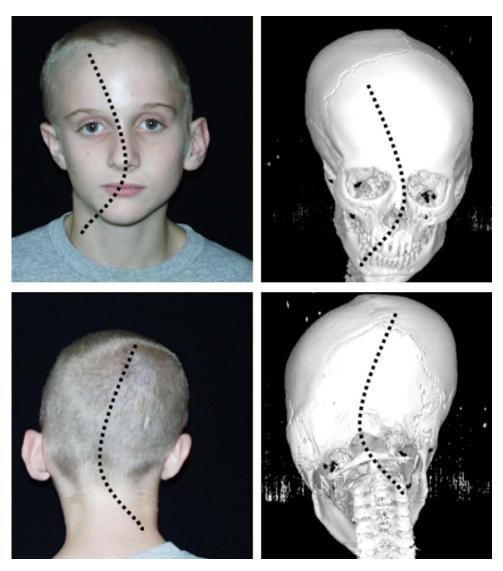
Clinical photographs and the corresponding 3D head CT images demonstrating the appearance of C-shaped facial scoliosis (dotted line) seen in a 12-year-old patient. Contralateral parietal bossing, ipsilateral ear prominence, and ipsilateral occipitoparietal flattening are particularly notable. Adapted with permission from Smartt JM, Russell RR, Singh DJ, et al. True lambdoid craniosynostosis: long-term results of surgical and conservative therapy. Plast Reconstr Surg. 2007;120: 993-1003. Per the licensing agreement, the Creative Commons license does not apply. Use of this material in any format is prohibited without written permission from the publisher, Wolters Kluwer Health, Inc. Please contact permissions@lww.com for further information.
